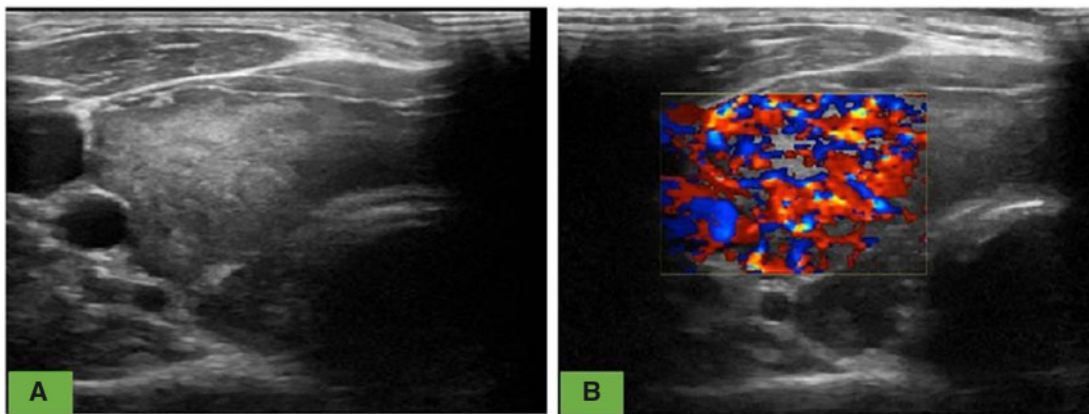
(A) demonstrates enlarged thyroid gland on ultrasound imaging and (B) shows increased vascularity of thyroid on colour Doppler.
